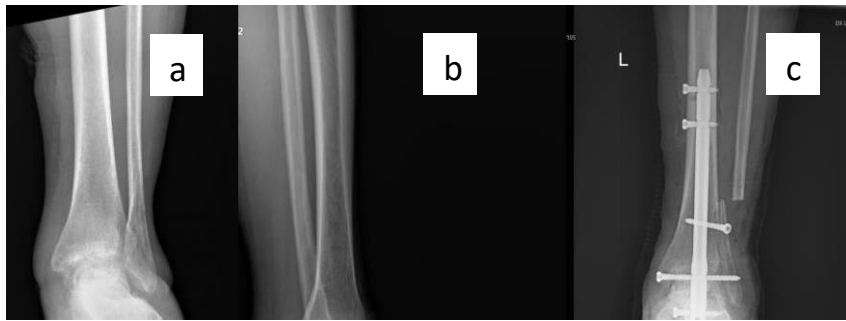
Preoperative ap and lateral ankle x-rays of 40 years old patient (a and b). Ap and lateral ankle x-rays after TTCA with retrograde intramedullary nail (c and d). Ap and lateral x-rays after removal of nail and intramedullary antibiotic spacer implementation (e and f).
